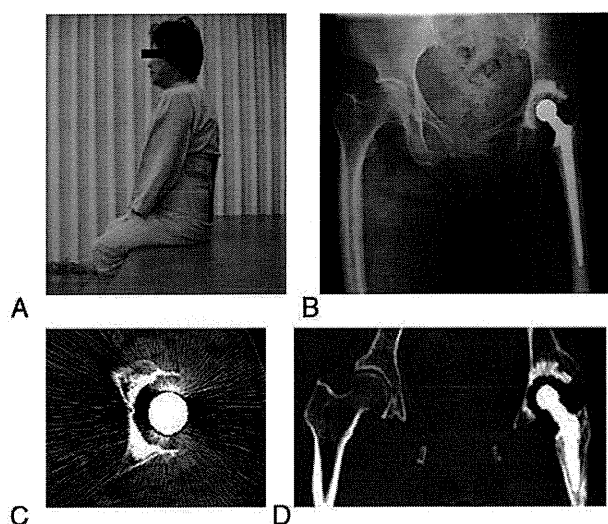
(A) Postoperative picture of the patient sitting on a chair. (B) A postoperative radiograph and computed tomograms (C, axial section, and D, coronal section) are shown.
